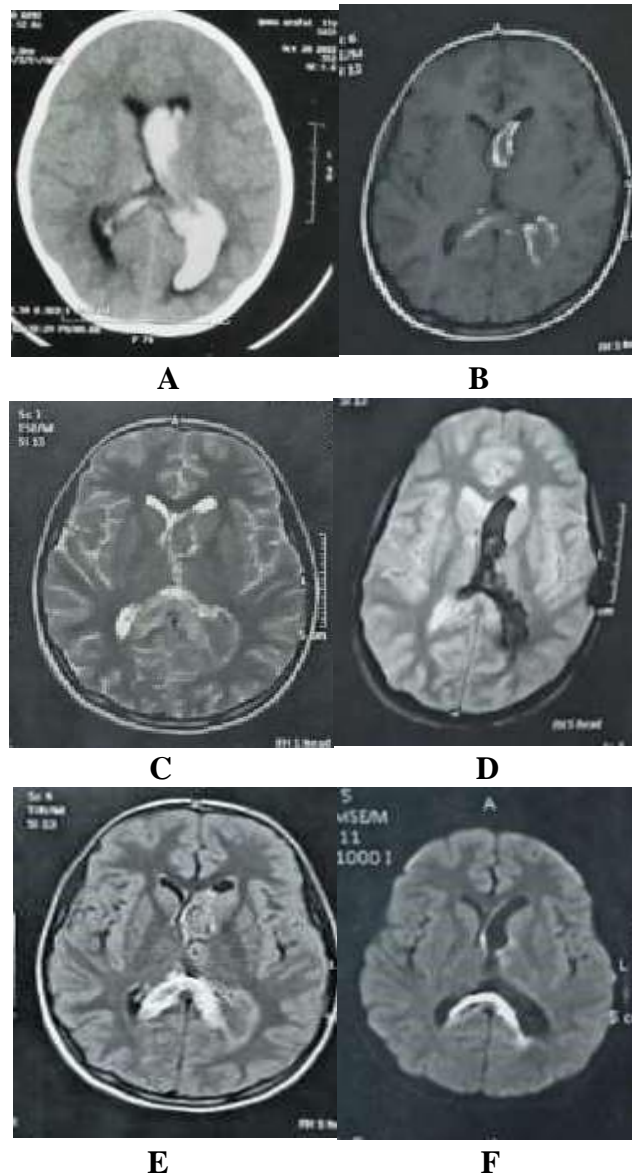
(A) axial CT images show hyperdense signal. (B) axial T1WI, show hyper intense signal within splenium of corpus callosum and left lateral ventricle, (C) axial T2 MRI images, show mixed hyper and hyposignal, (D) axial T2FFE show blooming signal, (E) axial FLAIR show mixed hyper and hyposignal intensity, , (F) axial DWIs show partial restricted diffusion
